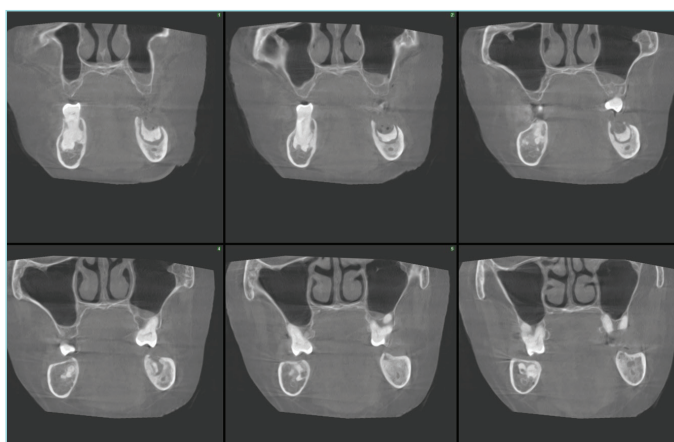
The coronal view of the patient in the CBCT. In this image, the relationship between the radiopaque lesions and the mandibular bone and teeth is clearly visible.
